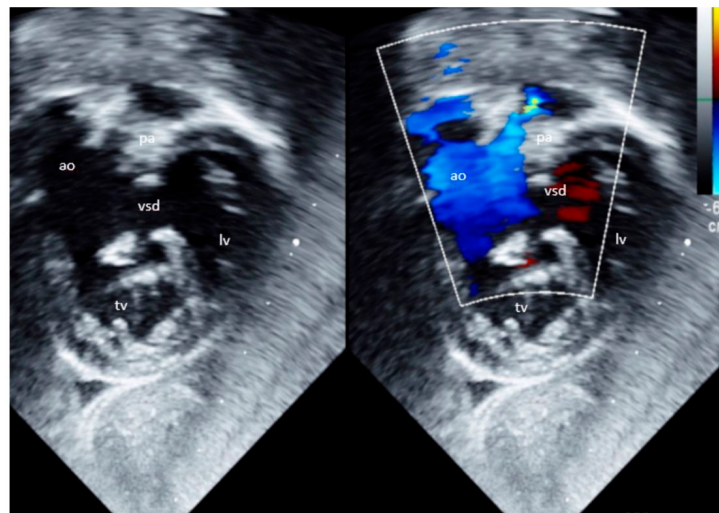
Subcostal transthoracic echocardiogram demonstrating subpulmonic VSD, a tricuspid pulmonary distance almost equal to the aortic annulus, fulfilling one of the criteria for the left ventricle to aorta commitability, aorta to the right of the pulmonary artery, and subvalvular and valvular pulmonary stenosis. AO: aorta, PA: pulmonary artery, TV: tricuspid valve, VSD: ventricular septal defect.
